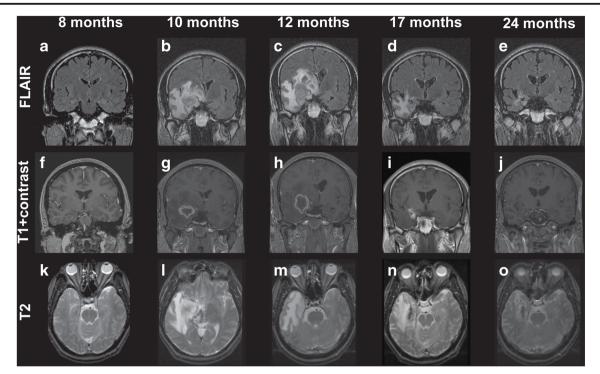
Development of radiologic changes in a patient with mesial temporal lobe epilepsy treated with a 24-Gy dose gamma knife stereotactic radiosurgery (SRS). FLAIR  $(\mathbf{a}-\mathbf{e})$  and T2  $(\mathbf{k}-\mathbf{o})$  hyperintensity appeared within the medial temporal lobe beginning by the 10th postoperative month and peaked in intensity at 12 months, corresponding to a decline in the proportion of patients experiencing
